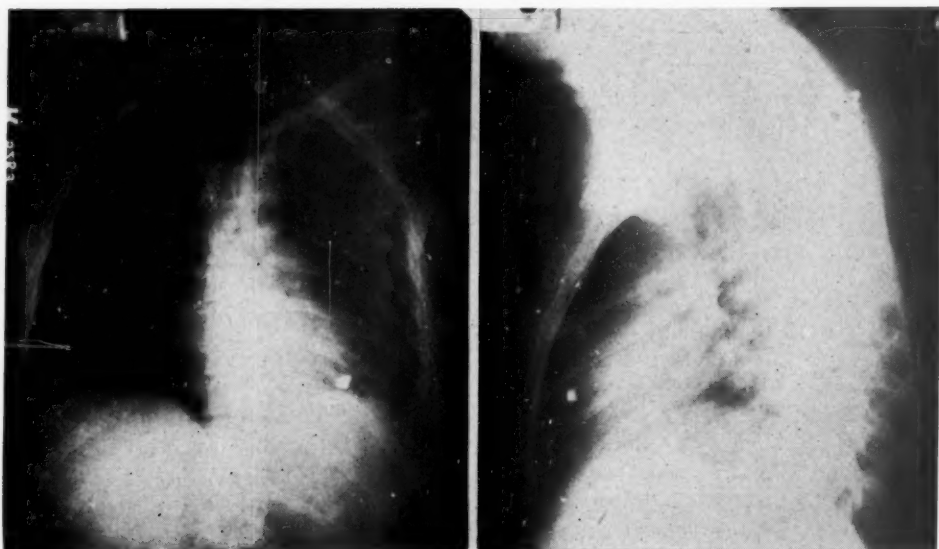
Posteroanterior and lateral roentgenograms of a missile in the left ventricle.
